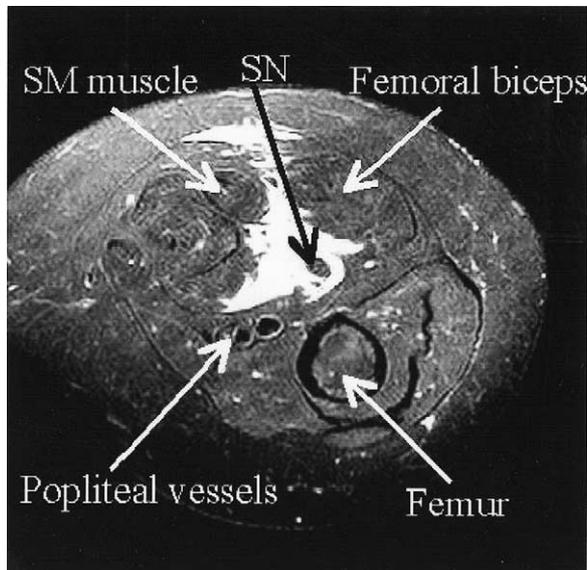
Magnetic resonance imaging (MRI) at the distal level of the thigh (90 mm above popliteal crease) 5 min after injection of 40 ml of local anesthesia. The arrow indicating the SN shows the direction of the stimulation needle with the posterior approach. The white area shows the diffusion of local anesthetic in the popliteal fossa fat. SM, Semimembranosus.
